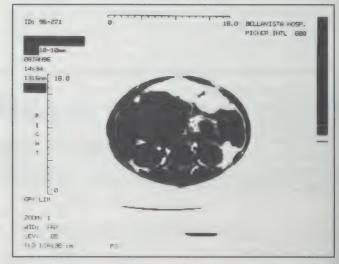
CT scan showing a large head of the pancreas tumor, solid tumor with some mall hypodense foci.
